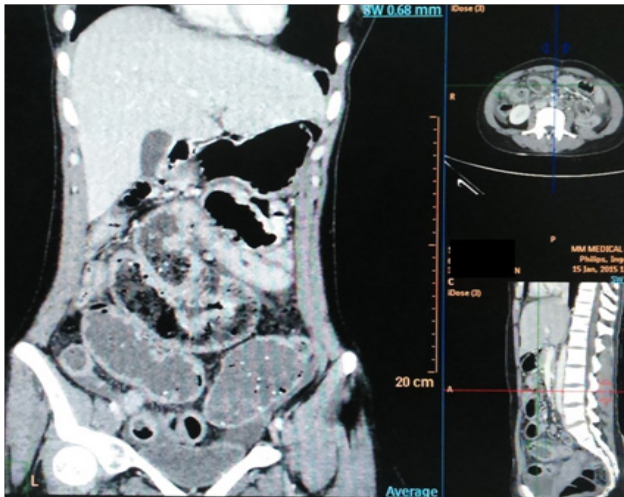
Contrast enhanced computed tomography (CECT) revealed an encapsulated form and loops are encircled inside of it.
